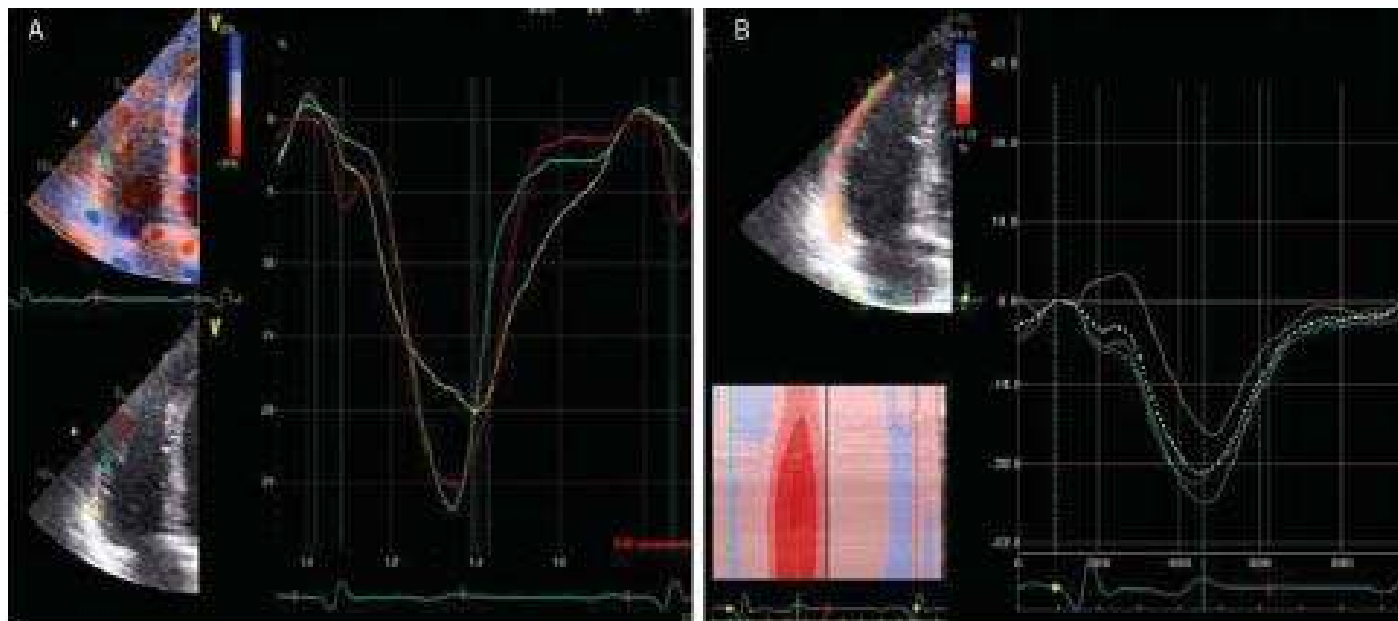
Strain measurements in the right ventricular free wall of a normal individual using tissue Doppler techniques (A) and speckle-tracking techniques (B).
